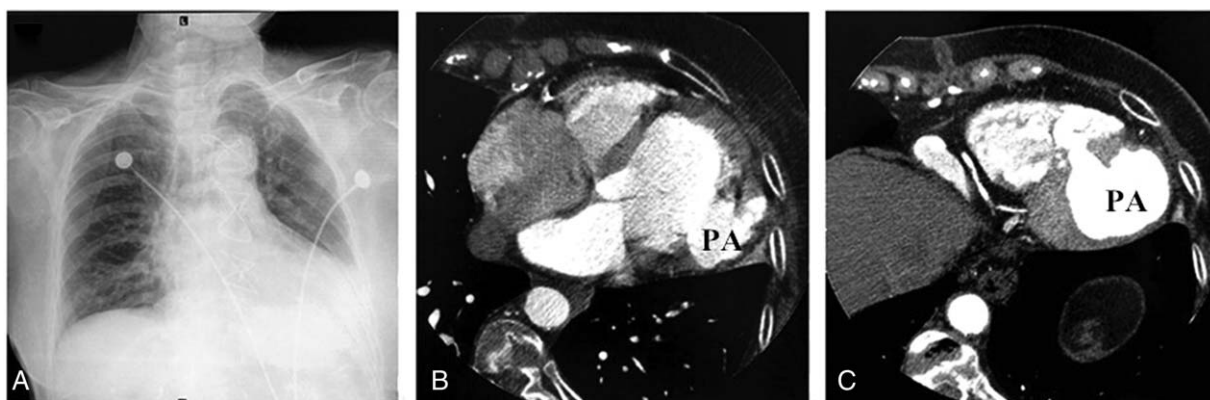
Patient no. 8. (A) Chest X-ray shows left ventricle amplification. (B) CTA shows a left ventricle pseudoaneurysm with a large orifice. (C) The black arrow shows the orifice communicating with the right ventricle. CTA=computed tomography angiogram, PA=pseudoaneurysm.
